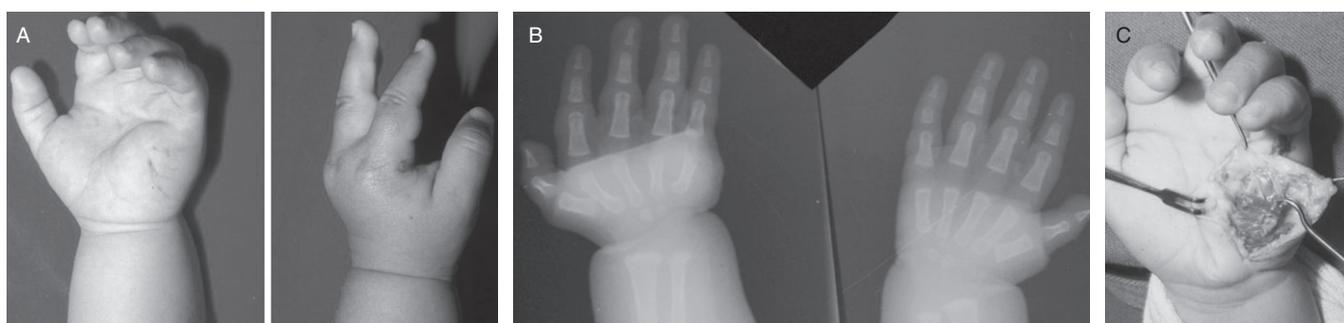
Case 4: 2-year, 6-month-old boy. (A) The left hand was affected. There was flexion deformity of the metacarpophalangeal joint of the fingers and bulky hypothenar eminence. (B) Roentgenogram revealed hypertrophic hand, ulnar deviation of the radial fingers at the metacarpophalangeal joints and widening of the intermetacarpal spaces on the right hand. (C) Intraoperative finding revealed aberrant muscles and hypertrophic intrinsic muscles in the hypothenar eminence.
